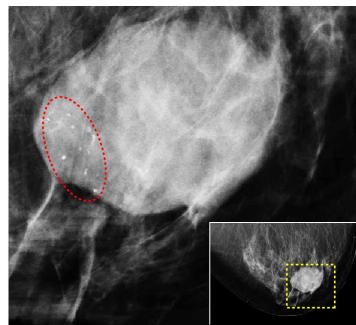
Magnified region-of-interest of craniocaudal x-ray mammogram (inset) of Case 2. Image shows oval mass with predominantly circumscribed borders with a small number of irregular microcalcifications within dotted red oval.
